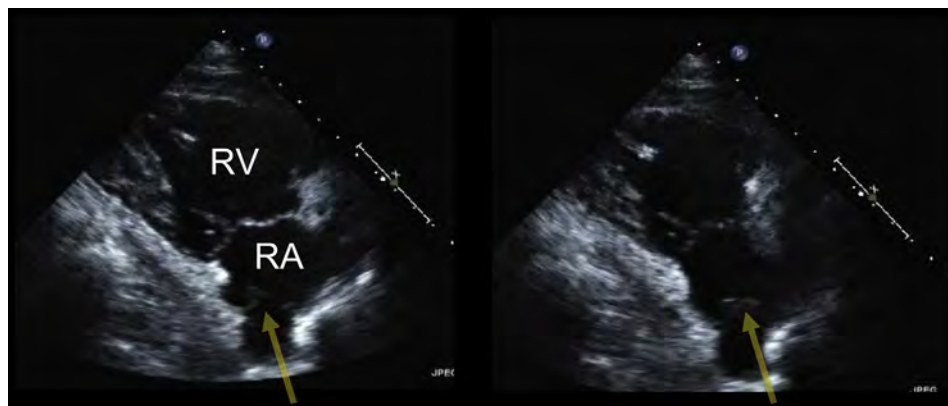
Transthoracic echocardiogram from the RV inflow view demonstrating mobile Chiari network (yellow arrows) attached to eustachian ridge.
